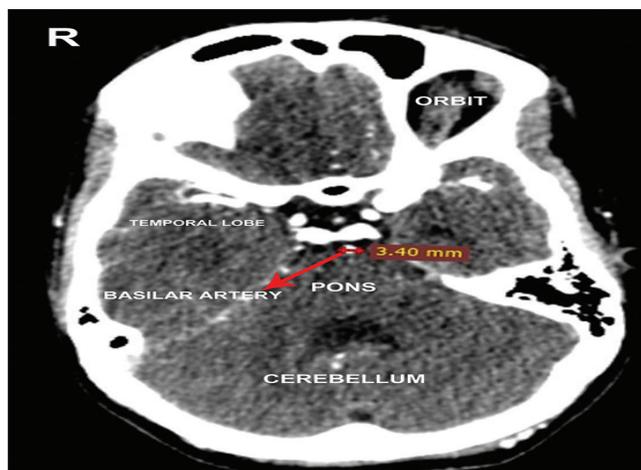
Axial source image of computed tomography angiography of brain showing measurement of basilar artery
